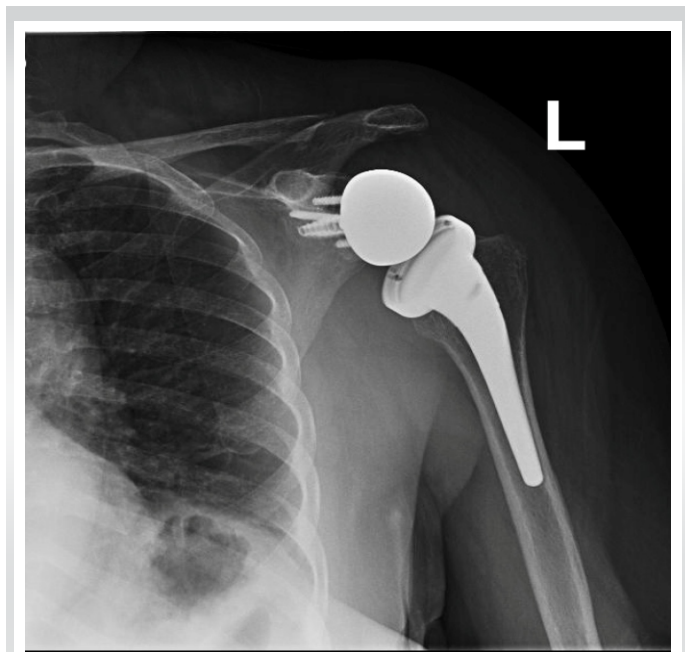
Anteroposterior radiographs of the right shoulder in February 2022 showing normal reverse total shoulder arthroplasty.
